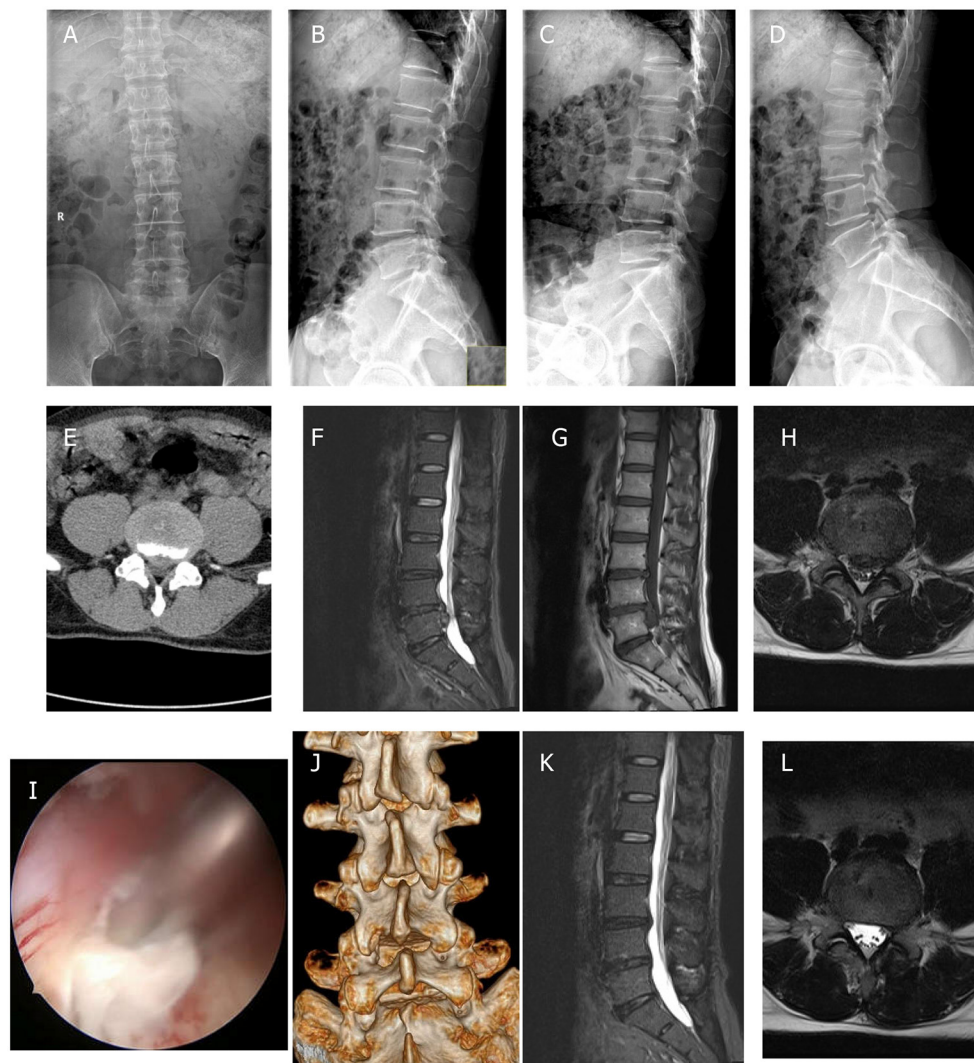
Unilateral biportal endoscopic (UBE) discectomy was performed on a 47-year-old male patient with L4/5 lumbar disc herniation. (A,B) Preoperative anteroposterior and lateral plain radiographs; (C,D) preoperative flexion and extension radiographs; (E) preoperative CT scans; (F–H) preoperative MRI scans; (I) discectomy was performed to ensure adequate decompression of the nerve tissue; (J) postoperative 3D-CT scans; and (K,L) postoperative MRI scans.
